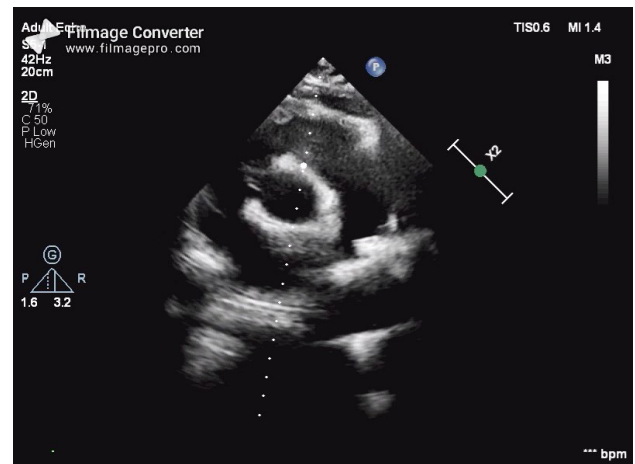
Echocardiogram After device closure
